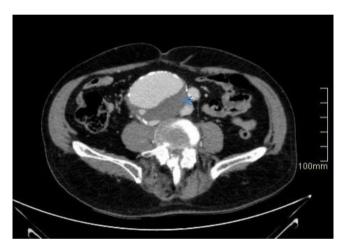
Computed tomography angiography (Coronal view). Blue arrow is pointing to isolated aneurysm with contained rupture of the right iliac artery
